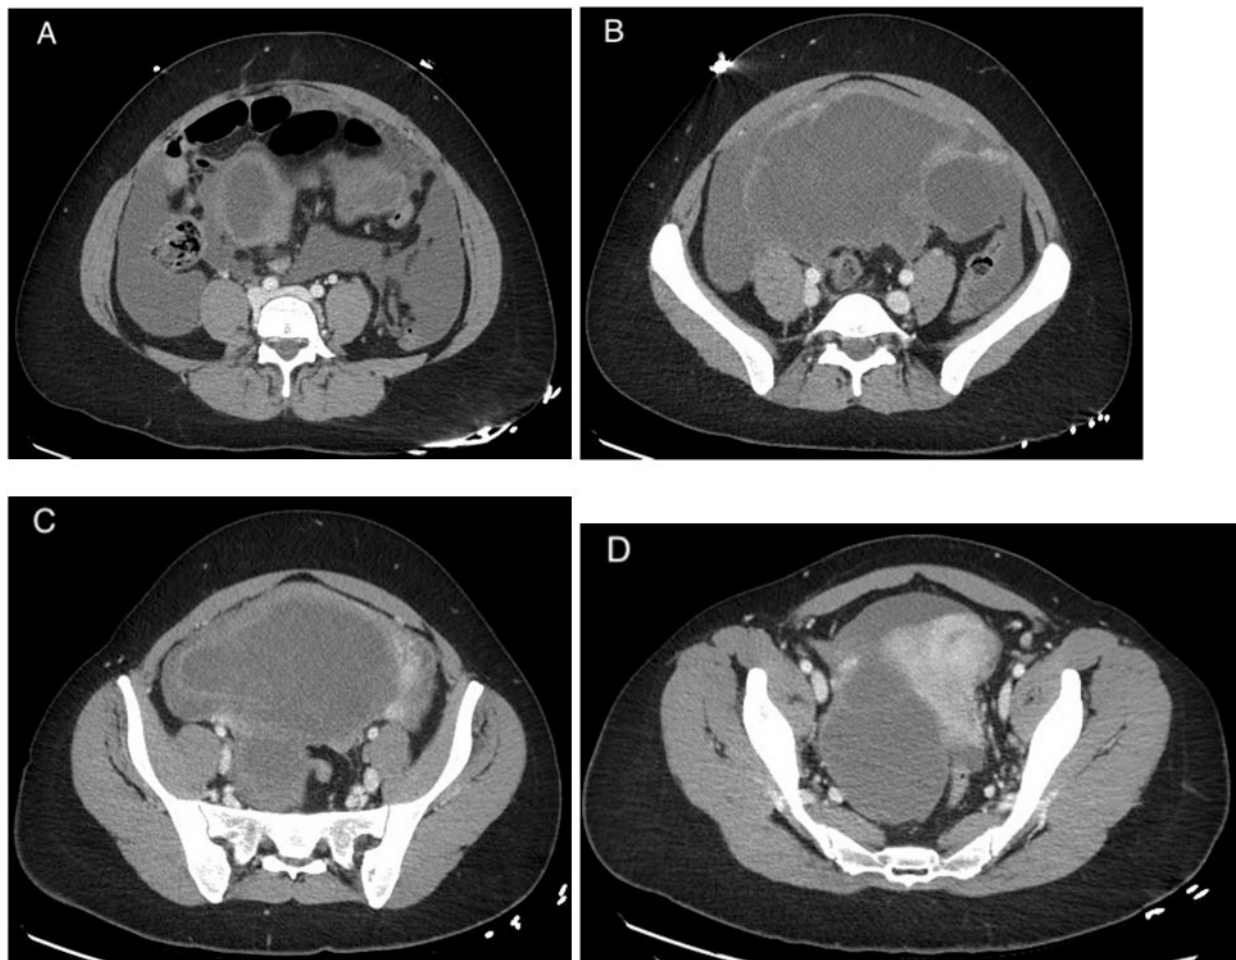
Transverse abdominal CT scan (A-D) shows extensive ascites and a large multiseptated, multicystic mass arising in the right pelvis and extending into the lower abdomen, measuring approximately 16 cm in maximal dimension.
